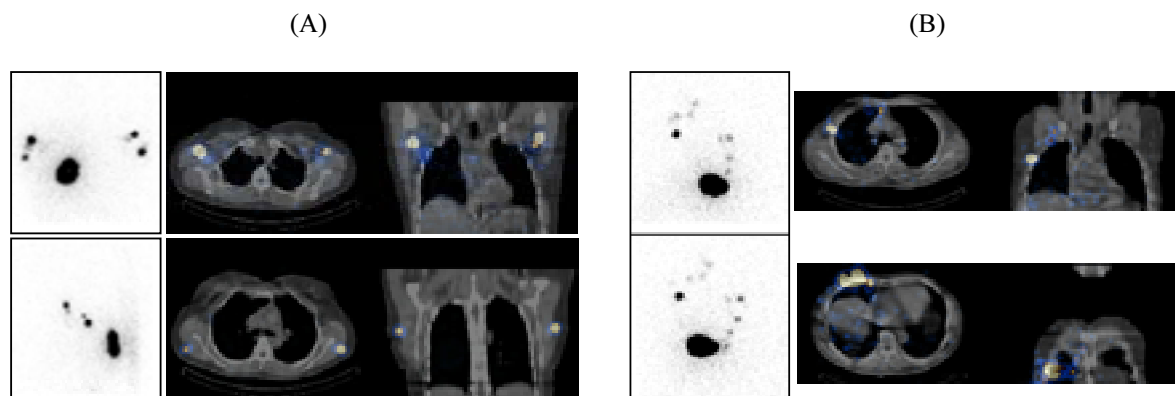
Additional information over planar scintigraphy provided by SPECT/CT in two patients with malignant cutaneous melanoma submitted to lymphoscintigraphy with ^{99m}Tc -albumin nanocolloid before radioguided sentinel lymph node biopsy. (A) Left panels show the planar posterior (top) and left lateral (bottom) views in a patient with melanoma located on her back: multiple bilateral lymph nodes can be detected, without however clear reference to precise anatomic structures. Right panels show SPECT/CT tomographic sections at different levels, demonstrating bilateral lymphatic draining to both axillary (top) and subscapular (bottom) lymph nodes. (B) Left panels show the planar right oblique (top) and anterior (bottom) views in a patient with melanoma located on his anterior right chest: multiple lymph nodes can be detected, without however clear reference to precise anatomic structures. Right panels show SPECT/CT tomographic sections at different levels, demonstrating lymphatic draining to both axillary and internal mammary chain lymph nodes
